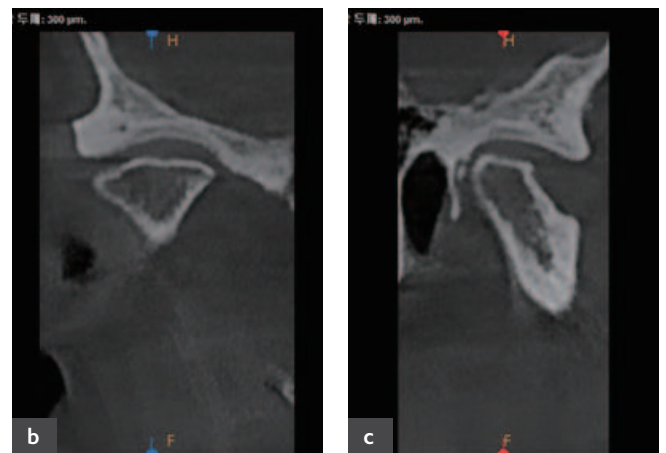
Panorama, CBCT images of Right Condyle at first visit
